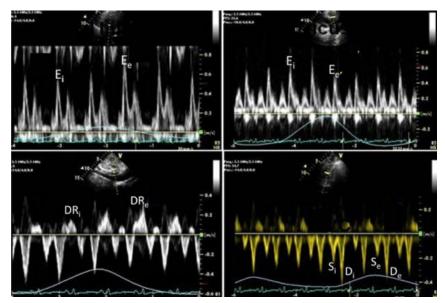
Characteristic PW Doppler echo findings of CP are shown with mitral inflow velocity (top left), tricuspid inflow velocity (top right), hepatic vein (bottom left), and SVC (bottom right), with simultaneous respirometric recording. E, DR_i, and S_i represent E velocity, diastolic reversal velocity, and systolic velocity, respectively, during inspiration. E_e, DR_e, and S_e represent E velocity, diastolic reversal velocity, and systolic velocity, respectively, during expiration.
